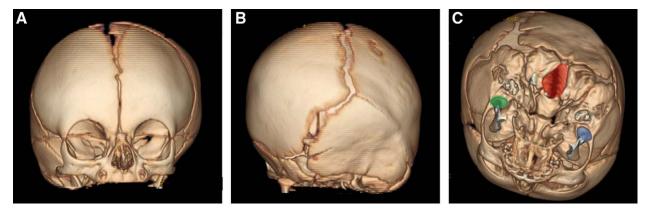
A, Frontal view 3D head CT of right unilateral craniosynostosis. Contralateral parietal bone bossing is visible. B, Posterior view 3D head CT of right unilateral craniosynostosis. Greater ipsilateral ear visibility can be explained by ipsilateral mastoid bulge pushing ear laterally. C, Cranial base view 3D head CT of right unilateral craniosynostosis. Foramen magnum (highlighted in red) is shifted toward the affected side, and contralateral glenoid fossa is shifted posteriorly (highlighted in green) compared to the ipsilateral fossa (blue), resulting in C-shaped convex ipsilateral facial scoliosis.
